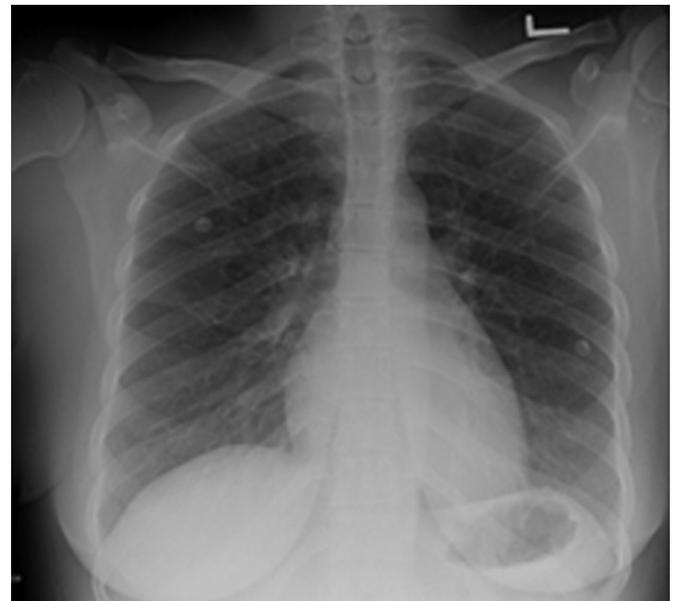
Chest X-ray showed clearing of opacities within 36–48 h after initiation of treatment.
